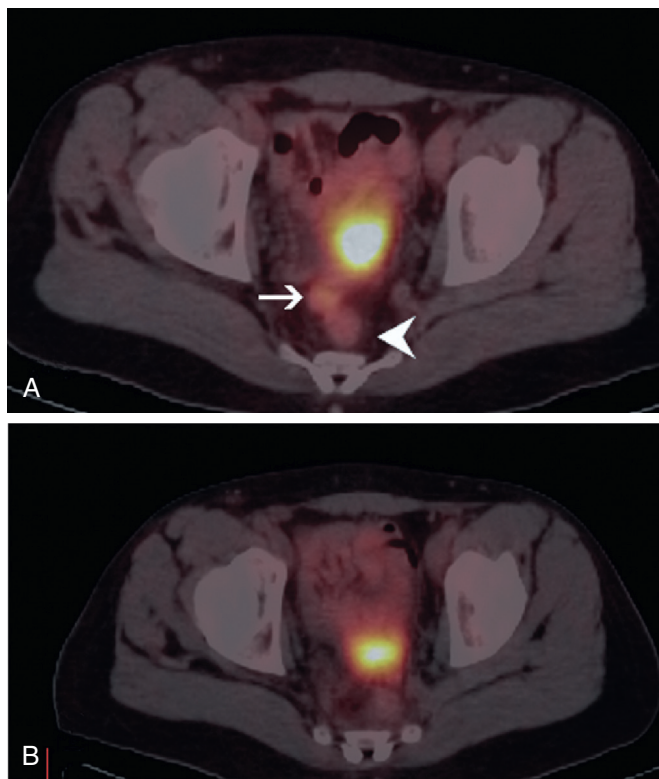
PET/CT for differentiating local recurrent from scar in a patient with colon cancer, status after low anterior resection. Recurrent disease was suspected based on increasing carcinoembryonic antigen (CEA) level. CT is not able to differentiate between scar and local recurrence. A, FDG-PET indicated an intense focus (arrow) suspicious for malignancy. A second mild focus was interpreted as scar (arrowhead). B, The diagnosis was confirmed surgically and the recurrent tumor was removed.
